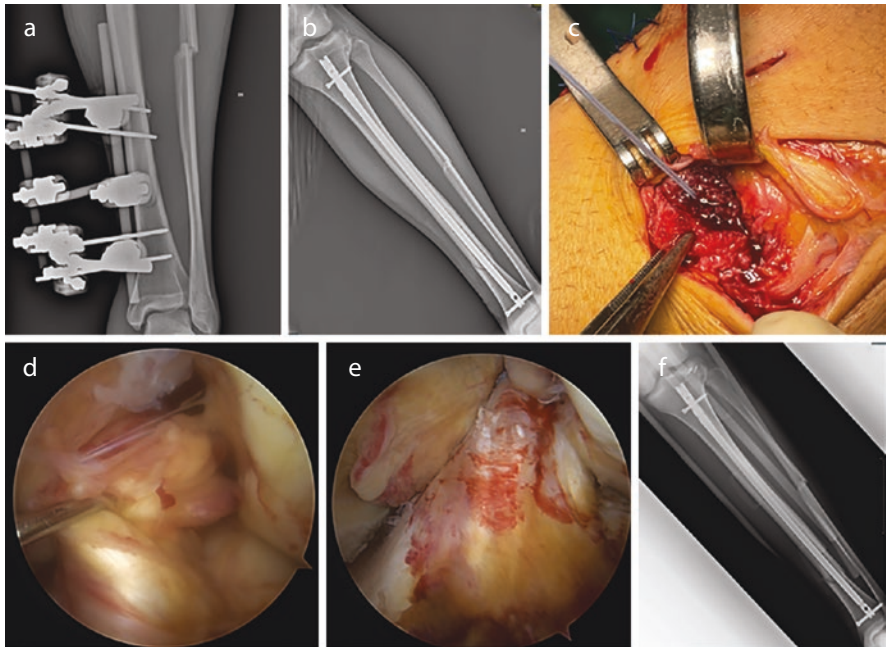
A very unusual ski injury: open leg fracture associated with an ipsilateral ACL tear and Segond's fracture. Comprehensive one-stage treatment (fracture fixation, ACL and Segond's fracture repair). (a) X-ray showing leg fracture after provisional external fixation; (b) X-ray after definitive intramedullary nailing before ACL and Segond's fracture repair; (c) Surgical finding after the first stage of the procedure (tibial fixation): Suture anchor repair of the Segond's fracture, identified as usual deep to the iliotibial tract and below the lateral meniscus; (d) Arthroscopy showing a repairable complete proximal ACL tear; (e) ACL tear as it appears after repair; (f) X-ray after comprehensive surgical treatment
